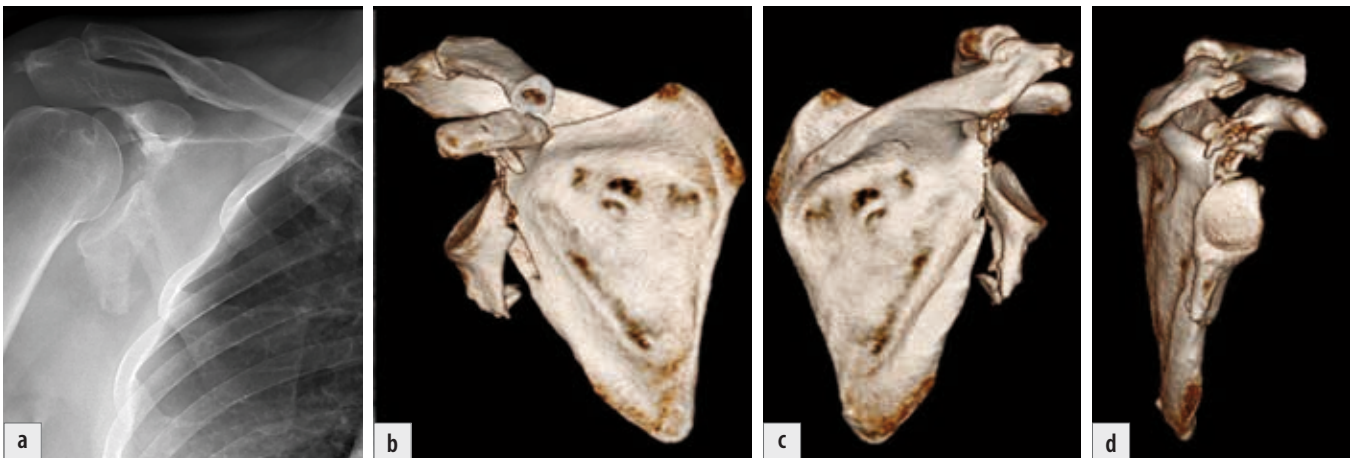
Fracture of the anatomical neck of the scapula: a) radiograph, Neer I projection; b) 3D CT reconstruction – anterior view; c) 3D CT reconstruction – posterior view; d) 3D CT reconstruction – lateral view.
